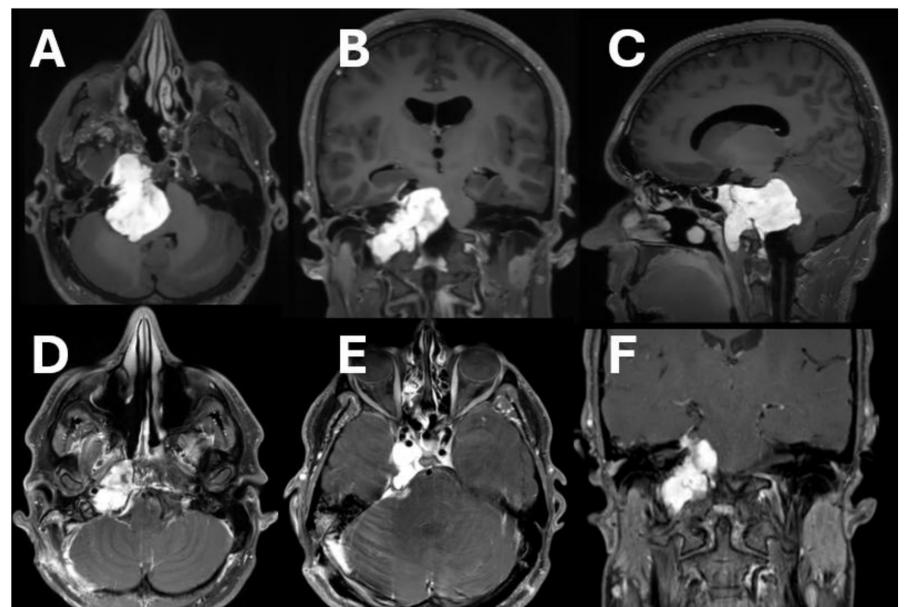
Brain MRI axial, coronal, and sagittal contrast-enhanced T1WI (A, B, C) demonstrating a large expansile lobulated multicompartmental heterogeneously enhancing lesion centered at the petroclival region with extension into middle and posterior fossae. Brain MRI axial, coronal, and sagittal contrast-enhanced T1WI (D, E, F) following staged resection of chondrosarcoma, showing marked improvement of mass effect on the brain stem and cerebellum, and the residual tumor at the right petrous bone and right cavernous sinus.
